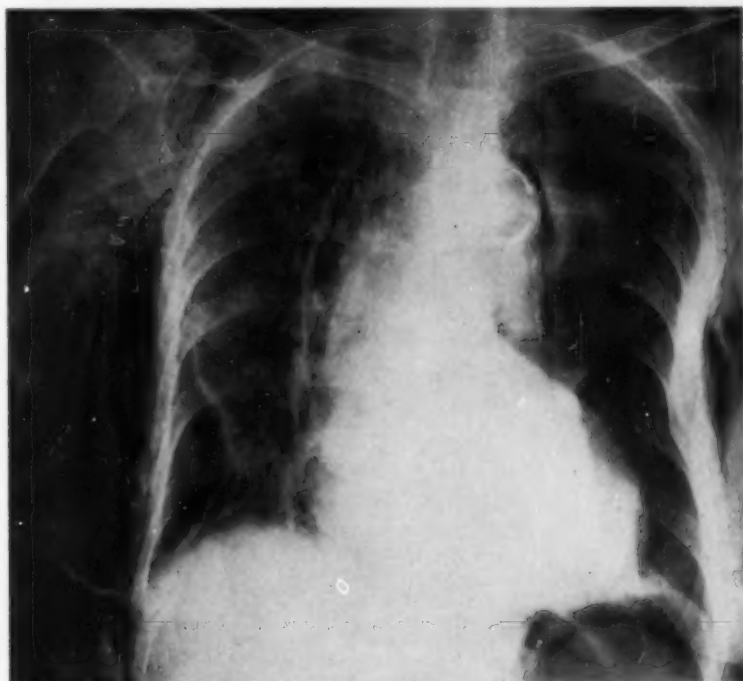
Upright chest roentgenogram taken November 4, 1956, showing fractured ribs and pneumothorax on the left, mediastinal and subcutaneous emphysema, air beneath the diaphragm and cardiac enlargement.
